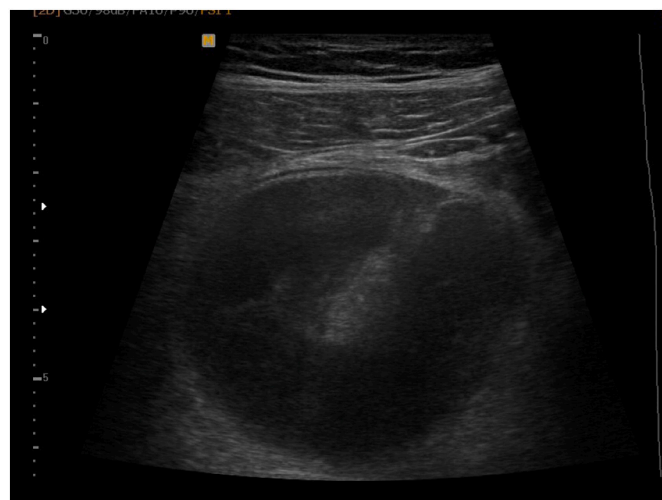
Transabdominal ultrasonography shows a ball-like loop of small intestine.
